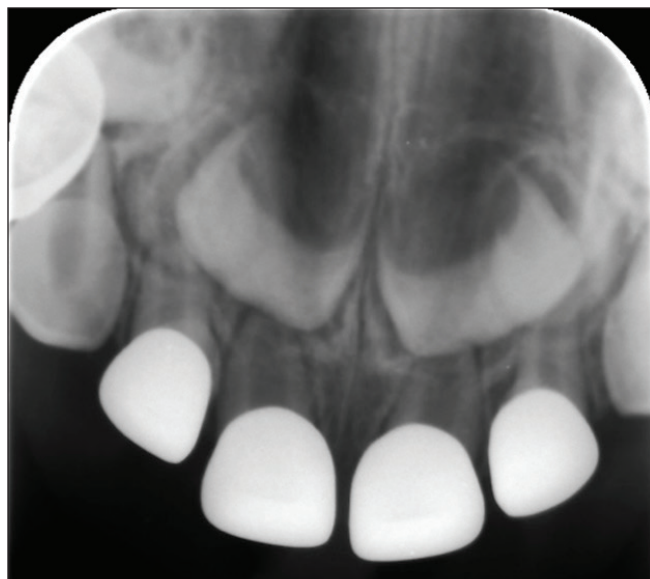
Radiograph of the traumatized lateral incisor. Slight enlargement of the PDL confirms the diagnosis of lateral luxation
